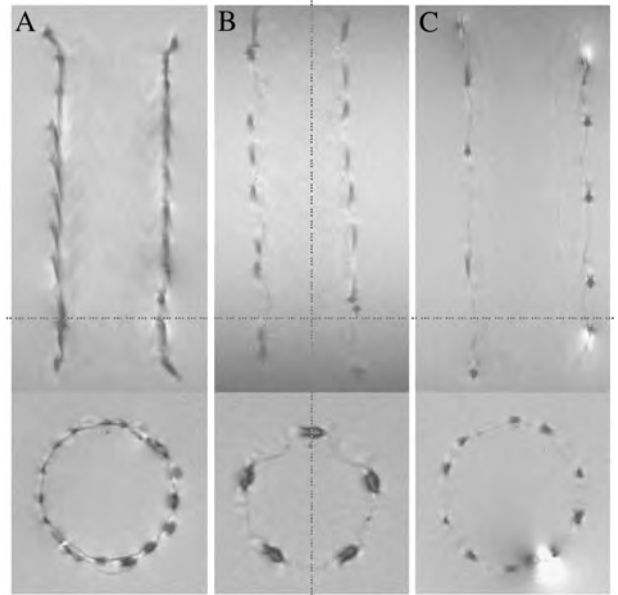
MRI-visualization of expanded stent-grafts (A-GoreTAG, B-Evita, C-Talent).
